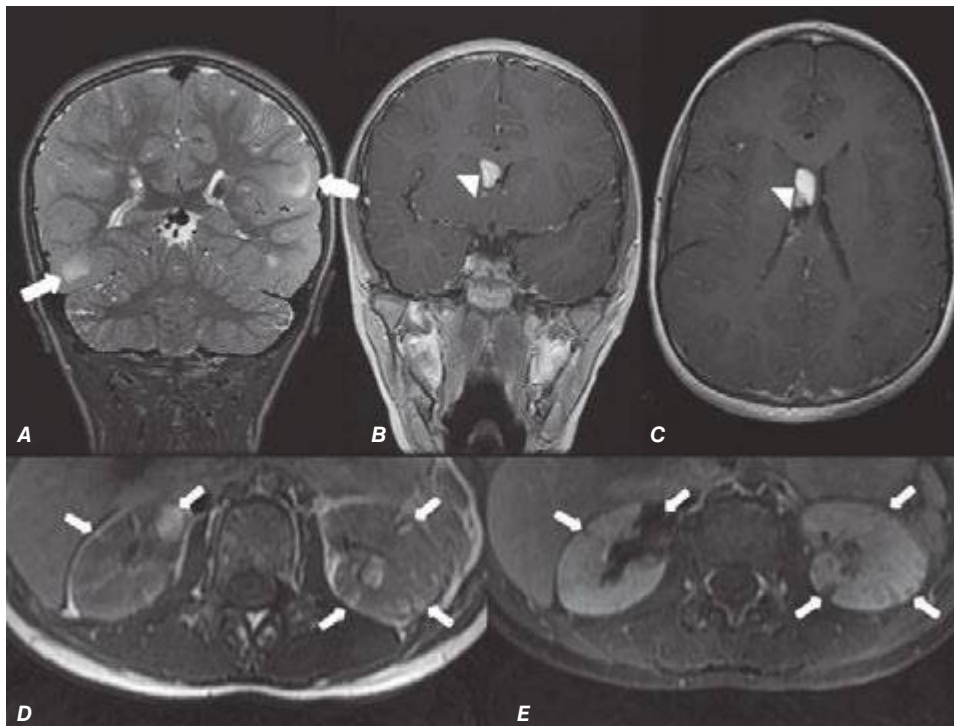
45 Tuberosclerosis (Chap. 118). Coronal T2-weighted MRI (A) shows multiple T2 hyperintense lesions in a cortical and subcortical distribution (*arrows*). Coronal and axial postcontrast T1-weighted image (B, C) demonstrates an expanding nodule with intense enhancement in the proximity of the right foramen of Monro, consistent with a subependymal giant-cell astrocytoma (SEGA) (*arrowheads*). Surveillance T1-weighted image (D) and postcontrast T1-weighted image with fat saturation (E) show multiple bilateral renal lesions with signal intensity of fat, consistent with angiomyolipomas (*small arrows*).
